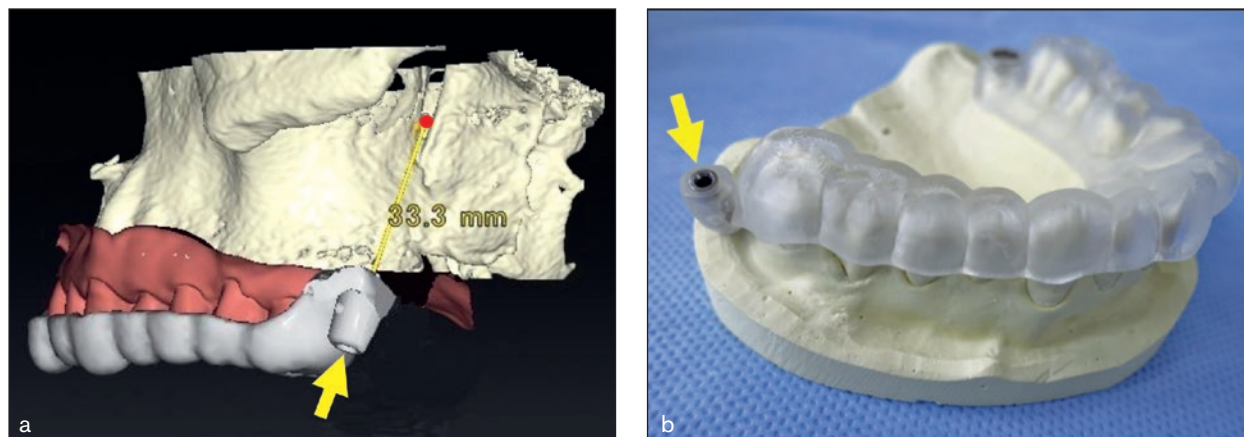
CAD/CAM injection guide based on the data obtained from CT and a plaster model. (a) After checking the sphenopalatine fossa with CT images, a point near the sphenopalatine fossa was determined as the target point (red circle) of botulinum neurotoxin injection. (b) A completed injection guide on the maxillary model. Arrows indicate the direction of needle insertion.
